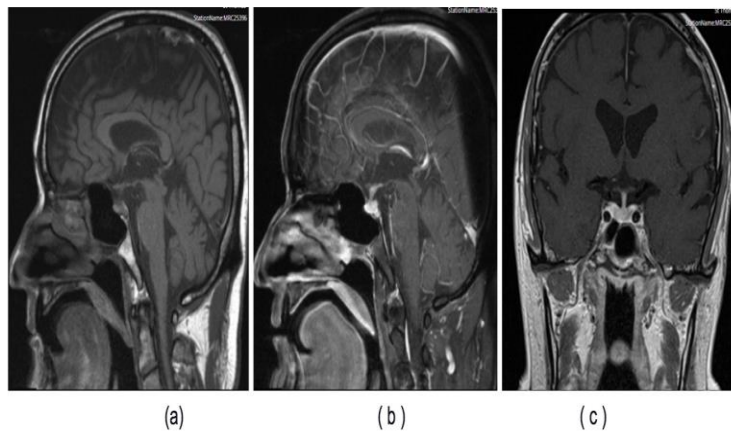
Pituitary MRI showing thickened infundibulum and a bulky pituitary. (a) Sagittal section - T1WI. (b) Sagittal section - T2WI. (c) Coronal section.
